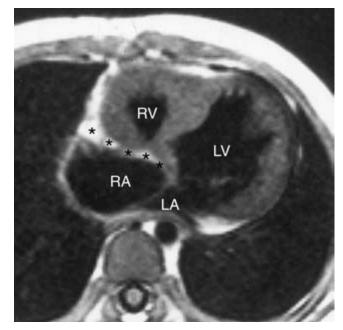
Absent right atrioventricular connection seen in T1weighted MR image. Notice that the epicardial fat tissue (asterisks) invaginates toward the center of the heart between the right atrium (RA) and the right ventricle (RV). LA = left atrium; LV = left ventricle.
